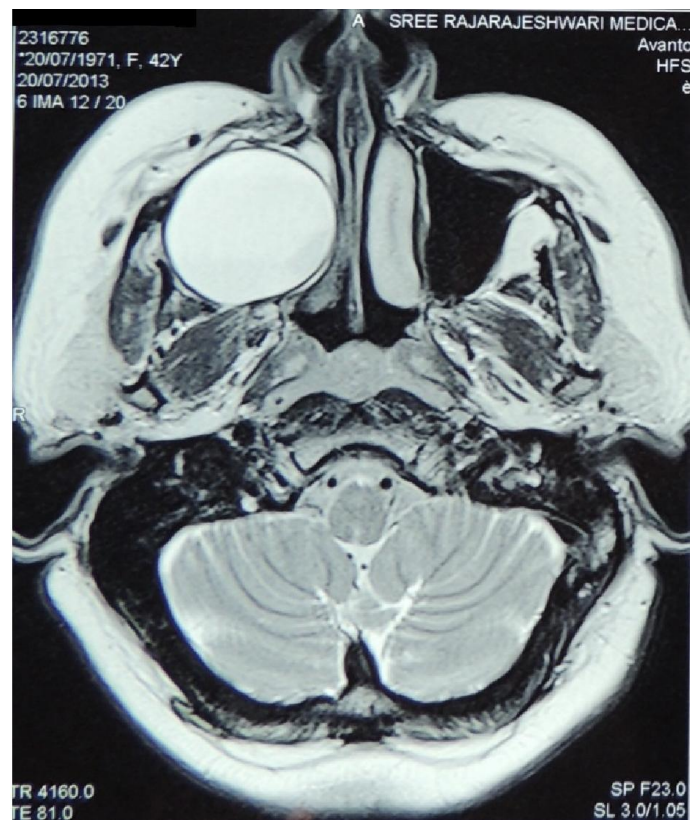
T2 weighted (MRI) axial section revealing a hyperintense collection involving right maxillary sinus
